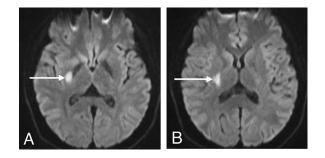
Infarction of the right putamen and internal capsule. (A and B) Hyperintensity of the right putamen and internal capsule on MRI-DWI (arrow).
